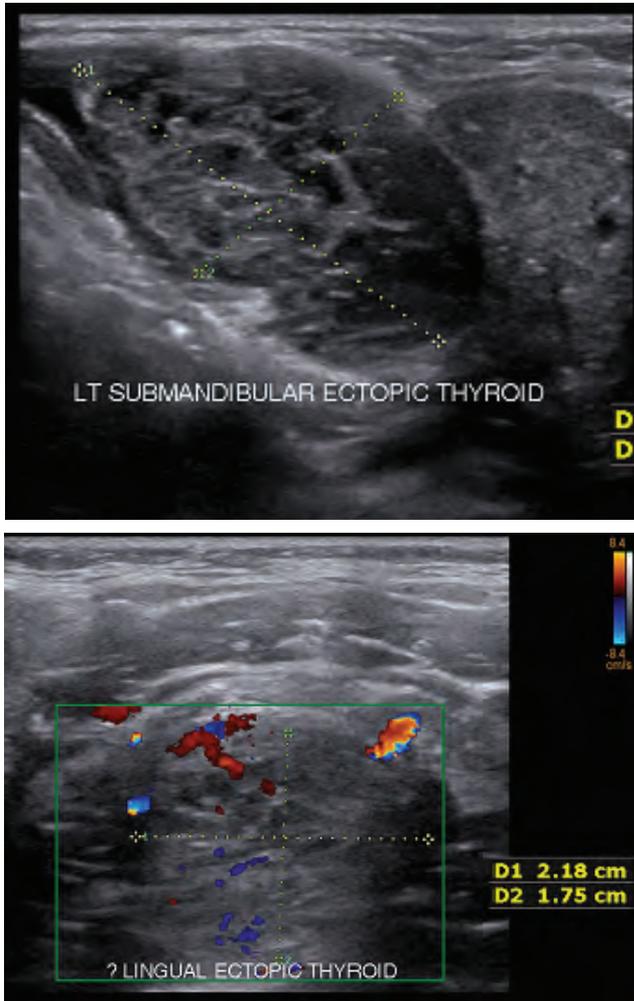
(a). Ultrasound image showing thyroid tissue like area in left submandibular region, Fig 2 (b). Ultrasound image of lingual region showing thyroid tissue like oval shaped area.
